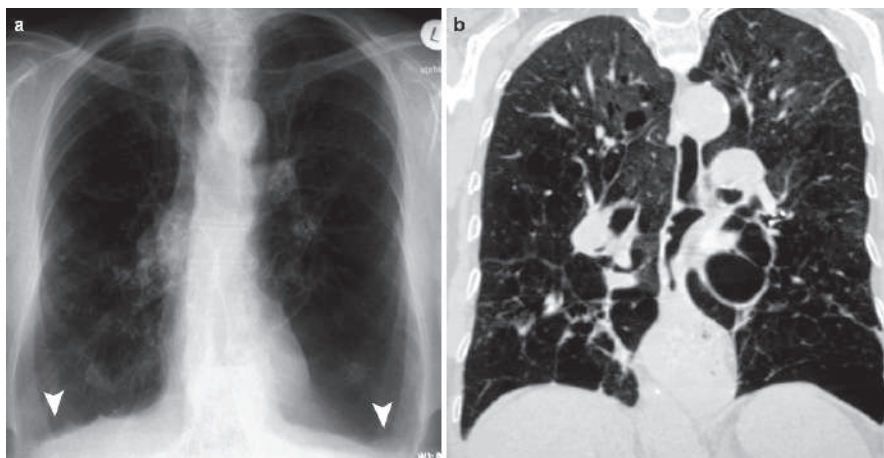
Posteroanterior plain chest radiograph (a) and coronal chest HRCT (b) of two patients with congenital α -1 antitrypsin deficiency disease shows flattened diaphragm in (a) (*arrowheads*), and bilateral panlobular and centrilobular emphysema in (b)
